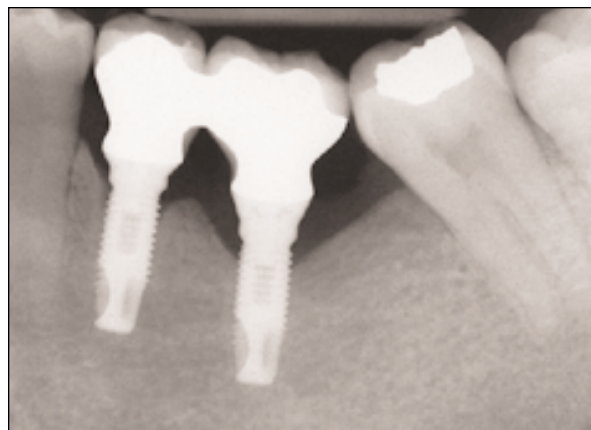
Radiograph taken at 12 months after modification of the implant restoration. Radiolucency at the previous defect sites was not seen.
